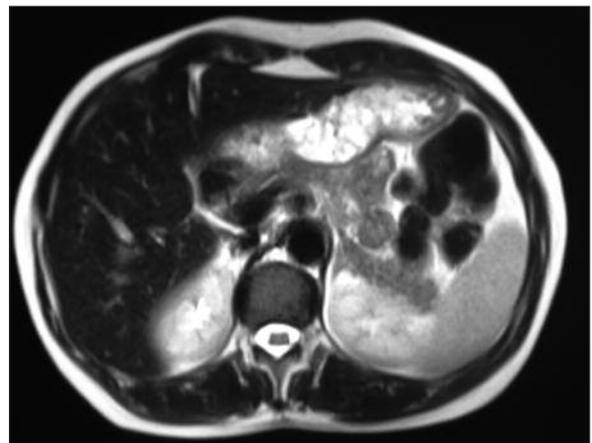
In MRI, there was no gallbladder in place.
